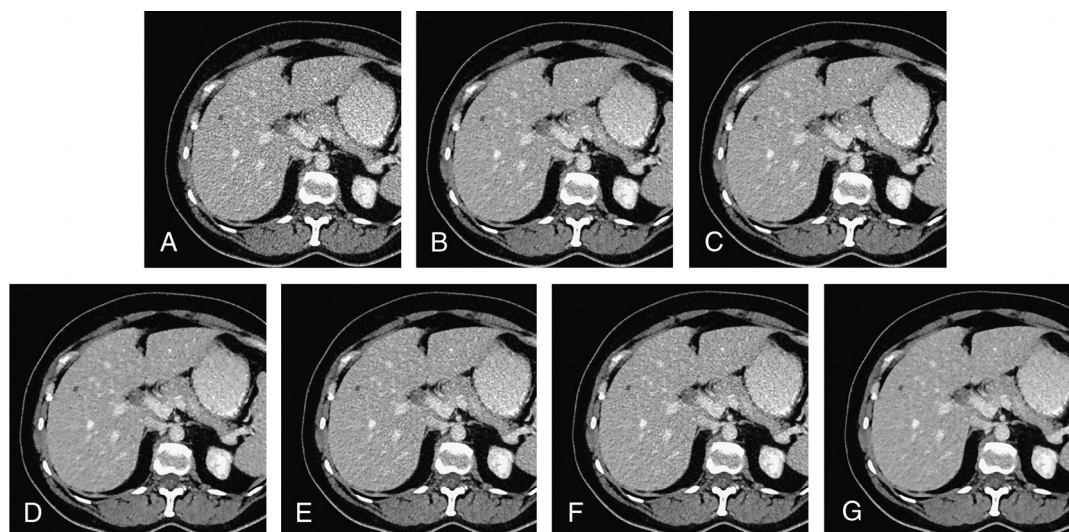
Transverse CT images in a 47-year-old female patient with a small cyst in liver segment V reconstructed with FBP (A), SAFIRE strength level 3 (B), 4 (C), 5 (D), and ADMIRE strength level 3 (E), 4 (F), 5 (G). Note the reduced IR-specific artifacts (pixilated, blotchy image appearance) on ADMIRE as compared with SAFIRE images, especially for ADMIRE 5.
